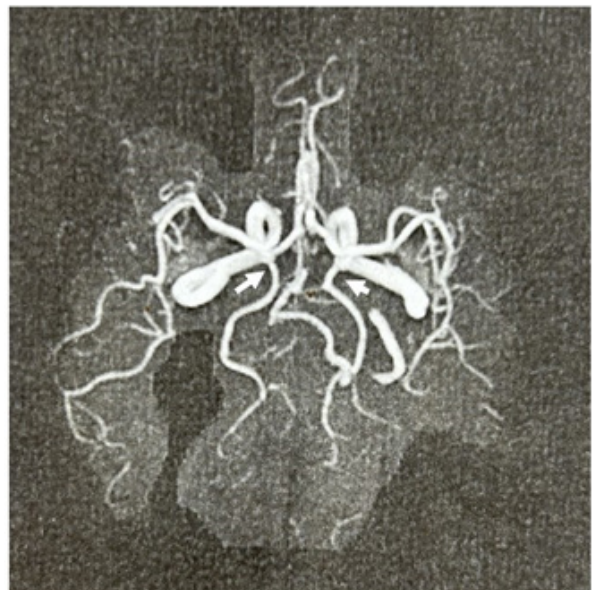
The MRI angiography shows an anatomic variation of the polygon of Willis, with a fetal pattern of both posterior cerebral arteries, which originated from internal carotid carotids (white arrows).
